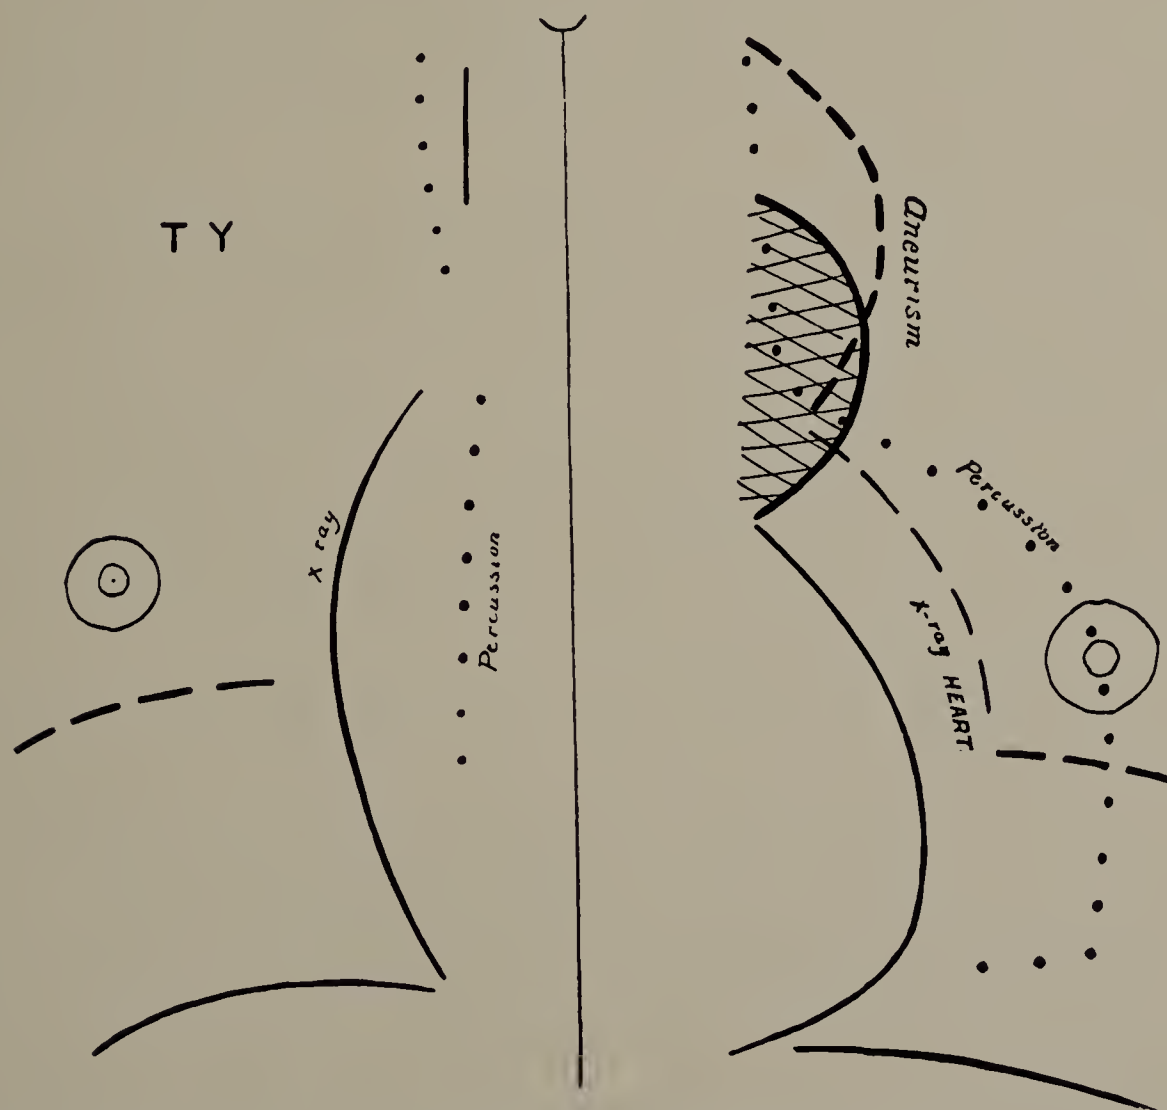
Case VII. The full and broken curved lines indicate the outlines of the aneurism and the heart in inspiration and expiration respectively as determined by X-ray examination; the dotted lines, the outlines as determined by percussion. The autopsy confirmed the correctness of the X-ray examination. The full and broken parallel lines indicate the position of the diaphragm in inspiration and expiration. (Cut one-third life size.)
